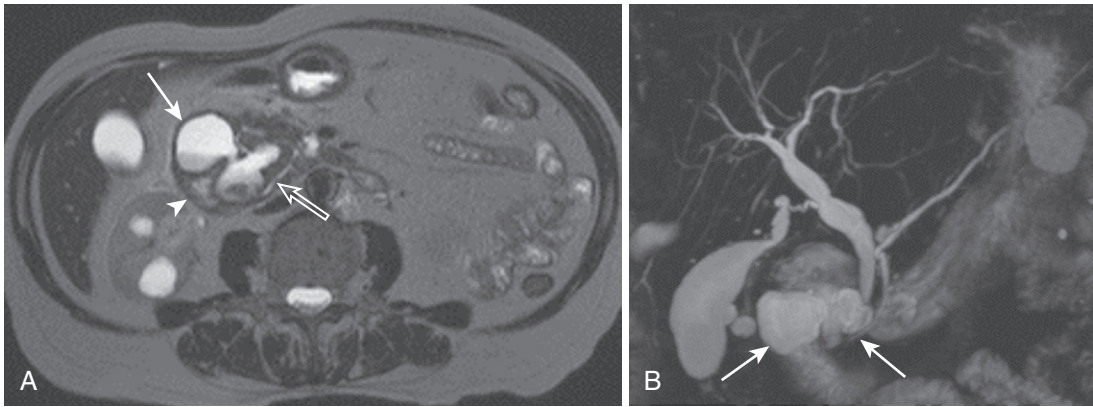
Cystic groove pancreatitis. A, The heavily T2-weighted image portrays a large, complex cystic lesion (*closed arrow*) in the pancreaticoduodenal groove between the duodenum (*arrowhead*) and the pancreatic head, displacing the main pancreatic duct (*open arrow*). B, The maximal intensity projection reconstructed from a 3-D MRCP shows the cystic lesion (*arrows*) between the distal CBD and the pancreatic duct and duodenum.
